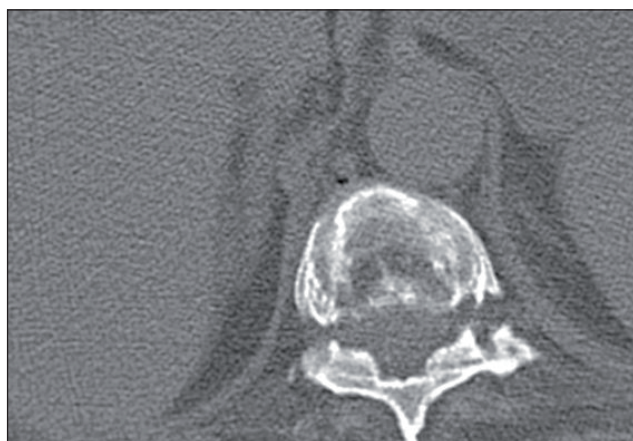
T10 vertebral compression fracture on axial CT.
